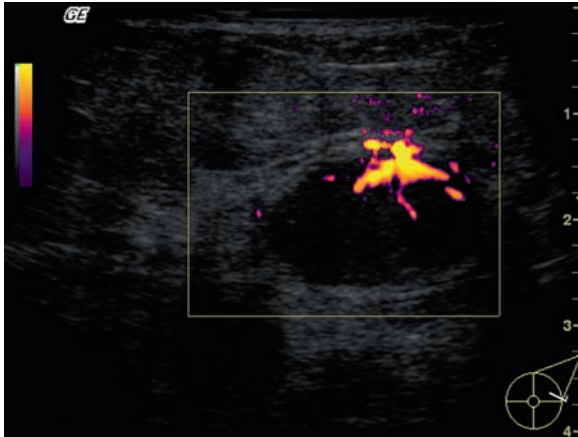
Ultrasound of a breast cyst within which there is an intracystic tumour (vascularity demonstrated using Doppler as white branched signal within the cyst; using false colour Doppler will demonstrate the vascularity even more prominently)
